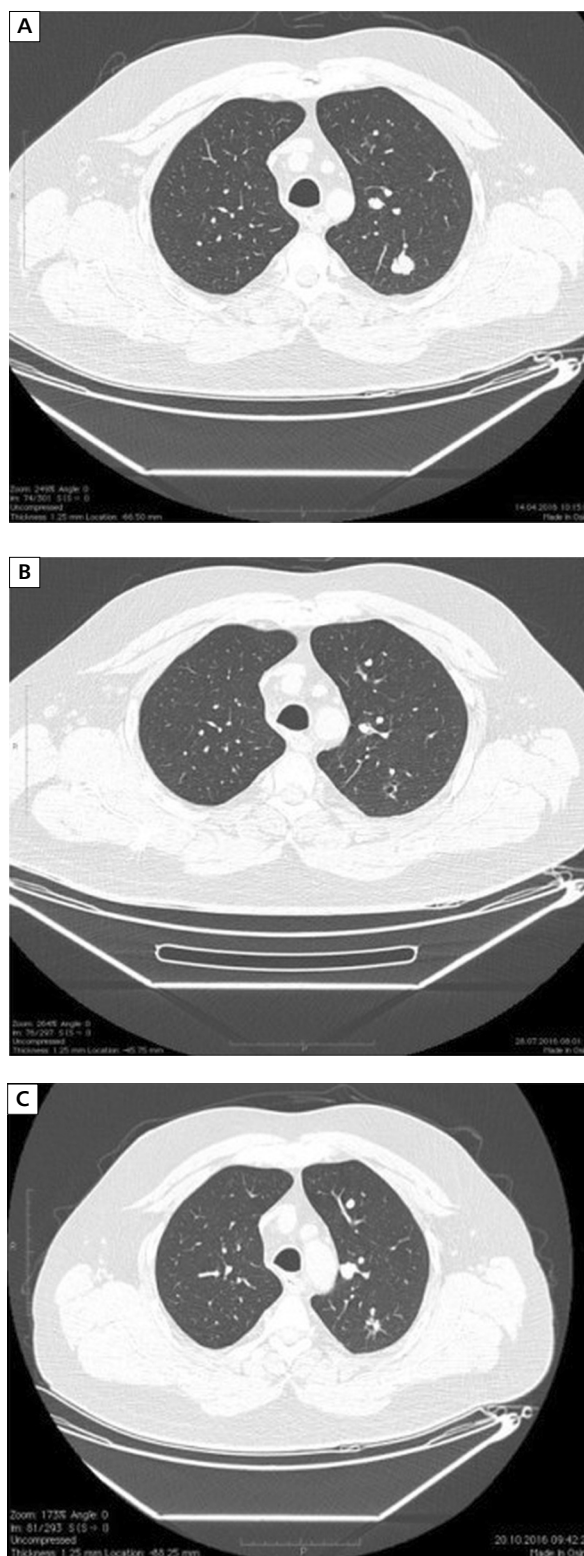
Monitoring of response to the treatment with docetaxel and nintedanib. A) CT scan performed at the moment of qualification of the patient to the therapy (April 2016); B) CT scan performed during the therapy showing a partial remission (July 2016); C) CT scan showing the progression of disease during therapy (November 2016)
